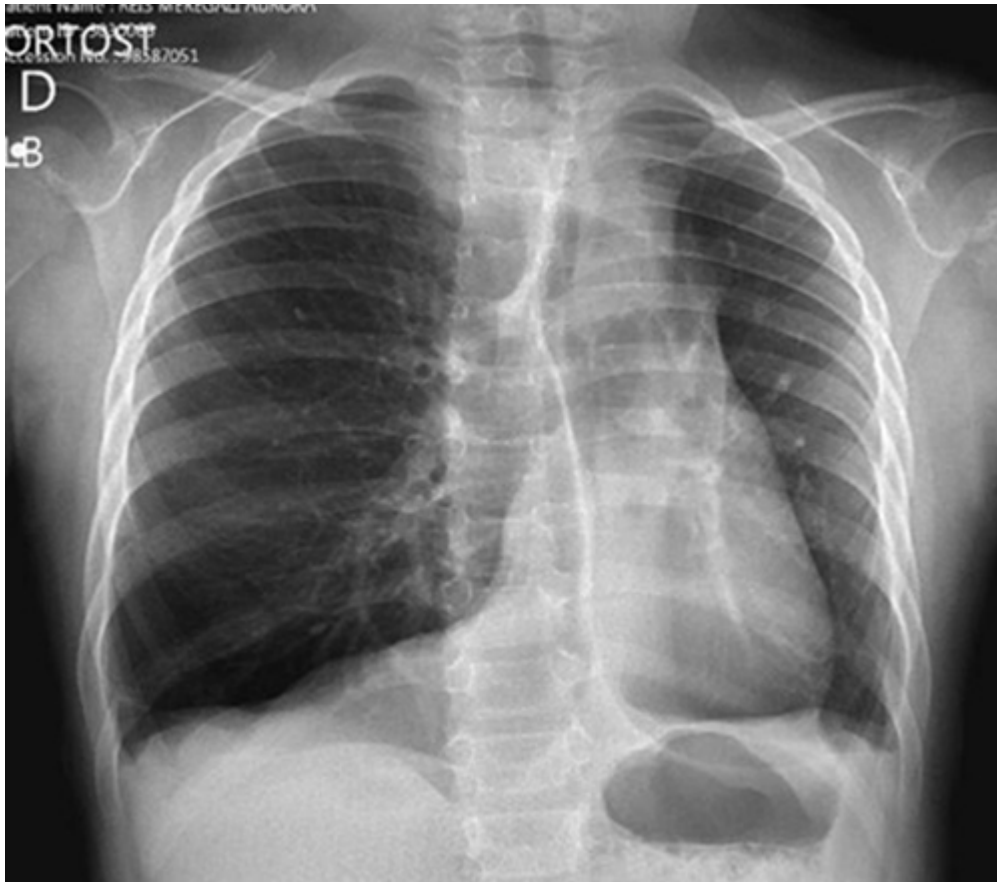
An X-ray at 5 years 3 months shows hyperexpansion of the right lung, with marked shifting of the right upper lobe into the left hemithorax (shifting of the anterior junction line), less marked displacement of the posterior junction line to the left and marked flattening of the right hemidiaphragm. There is diffuse thickening of the bronchial walls and persistent leftward mediastinal shift with complete atelectasis of the left lower lobe (seen behind the heart). [↩](#)
